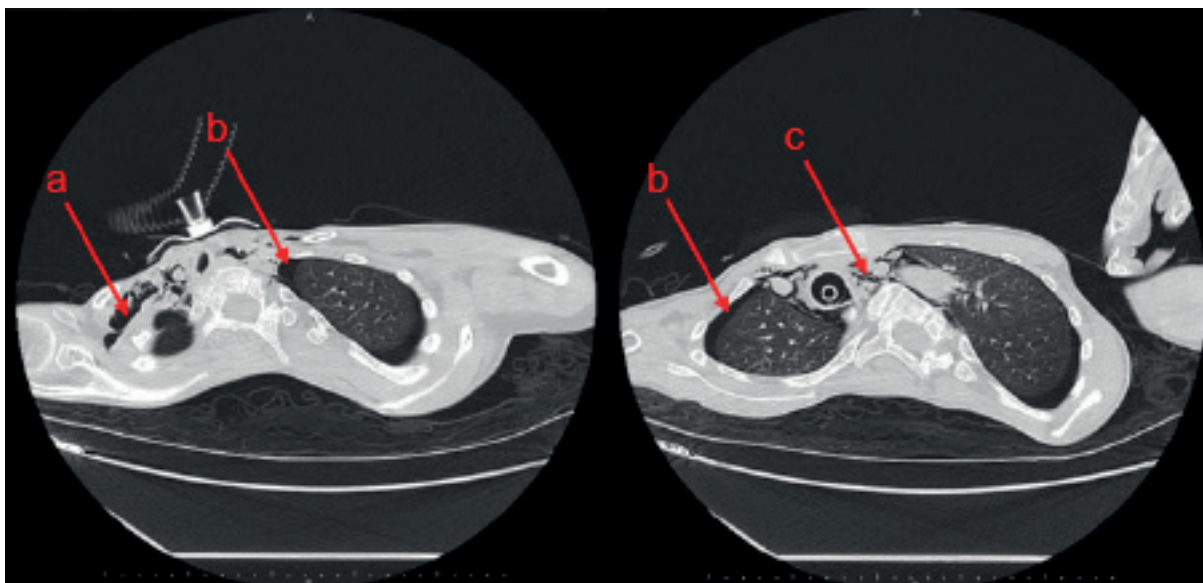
Computed tomography images showing pathologic findings in the neck and chest (a: subcutaneous emphysema; b: pneumothorax; c: pneumomediastinum)
